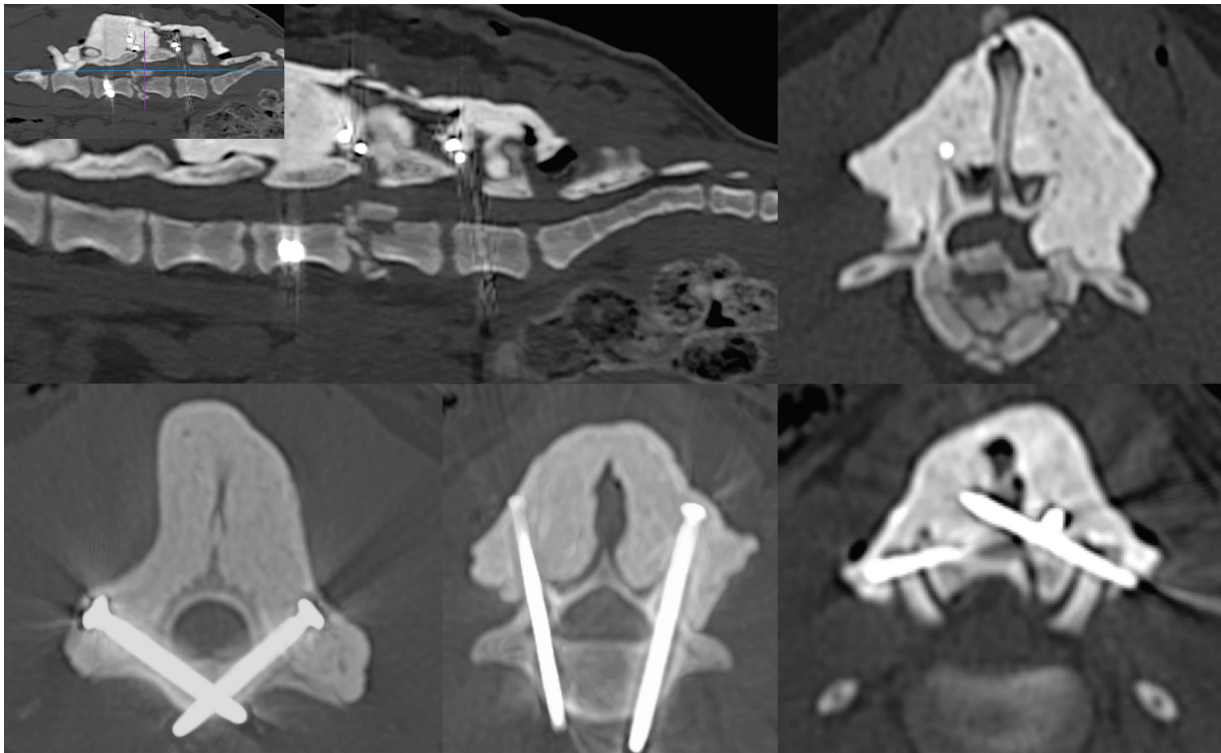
Postoperative computed tomographic multiplanar reconstruction (MPR) sagittal (top left) and transverse plane images at the level of cranial L6 (top right), L5 (bottom left), L7 (bottom middle), and L6/L7 zygapophyseal joints (bottom right), demonstrating good alignment of the floor of the vertebral canal with improvement in spinal cord compression and optimal placement of implants in L5 and L7. Insert top left indicates the level of the transverse plane image top right.
